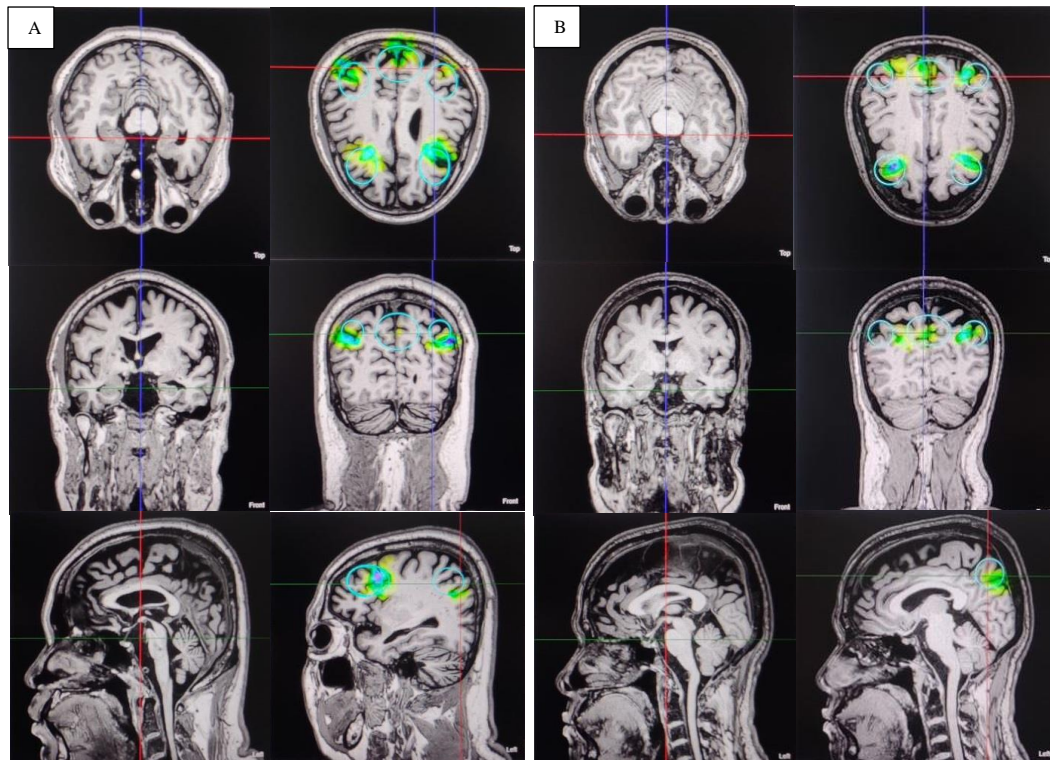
Head CT scan after TPS stimulation; (A) Patient of Case 1, (B) Patient of Case 2
